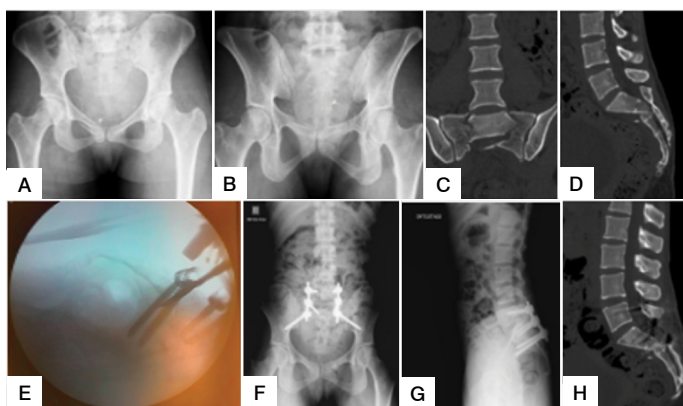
Female patient, 31 years old, a victim of a 3-meter fall. On neurological examination, Gibbons 4. Complementary imaging exams: a) Inlet radiography of the pelvis; b) radiography in the outlet view of the pelvis. Note the seemingly innocent radiographs; c) CT coronal reconstruction showing a “U” fracture pattern, with two vertical lines and one horizontal line, conceptually constituting a spinopelvic dissociation; d) Sagittal CT reconstruction showing flexion and posterior translation of the proximal fragment with bone compression of the central canal; e) intraoperative fluoroscopy with reduction maneuver by direct manipulation with an osteotome; f) postoperative radiograph in anteroposterior (AP) view; g) postoperative radiograph in the lateral view; h) Postoperative CT: sagittal reconstruction shows satisfactory reduction and decompression. A clinical segment of the patient showed considerable neurological recovery.
